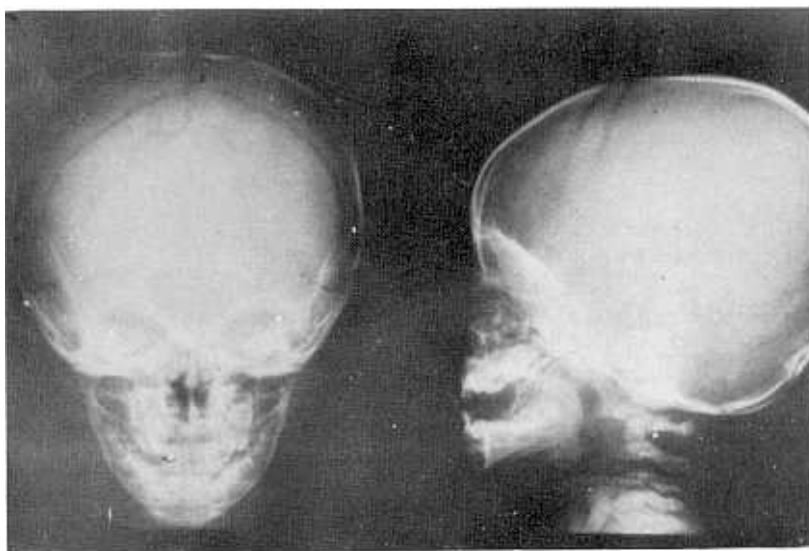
Case 3. Skull x-ray films show separated suture lines but there is no intracranial calcifications.
